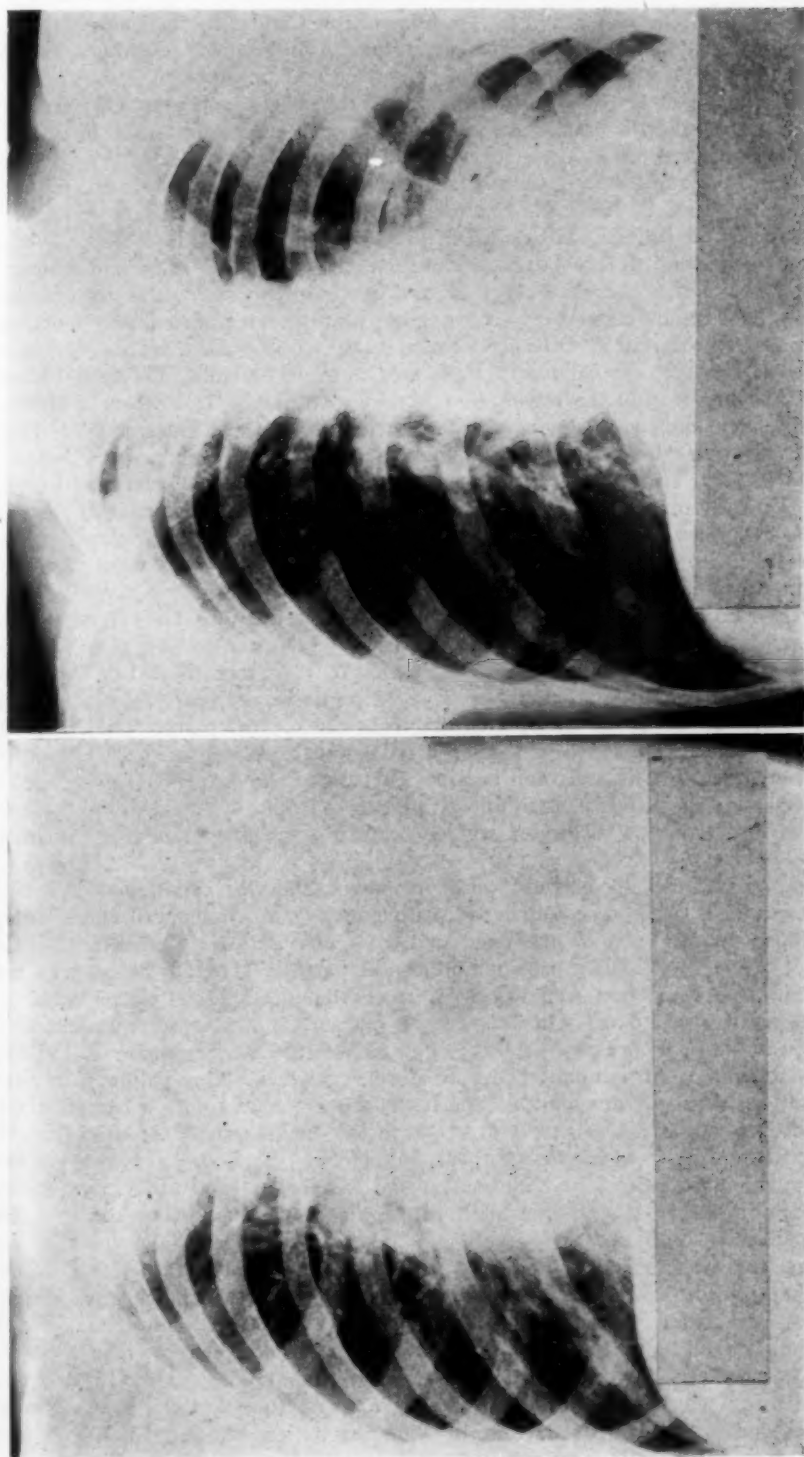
Roentgenograms of case 3 (left, June 26, 1942; right, October 6, 1942). Onset of empyema about April 11, 1942. Five thoracenteses were done between June 26 and July 15, 1942. The last roentgenogram showed only a moderate degree of thickened pleura.
